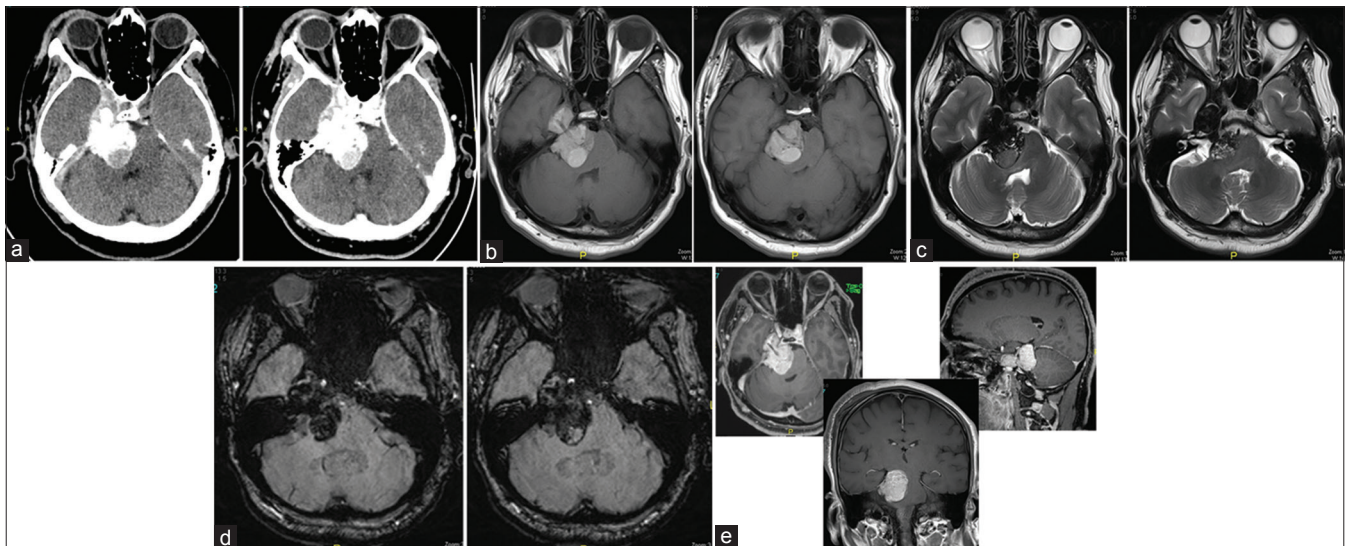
(a) Axial CT sections before and after IV contrast administration showing right-sided CP angle extra-axial mass lesion of mixed high and iso-attenuation value showing faint postcontrast enhancement extending over the petrous apex to the right parasellar region medial to the right temporal lobe. (b) Axial T1-weighted images showing lobulated intracranial extra-axial hyperintense lesion at the right CP angle and creeping along the petrous apex to the right parasellar region compressing the brain stem and indenting the medial aspect of the right temporal lobe. (c) Axial T2-weighted images showing the complex texture of the lesion with predominant low signal intensity and cystic areas of iso to high signal intensity. (d) Axial susceptibility-weighted images (SWI) showing ferromagnetic effects of the contents of the lesion with patchy areas of low signal intensity within a cystic lesion. (e) Axial, sagittal, and coronal contrast-enhanced T1-weighted images of the brain showing increase in the hyperintensity of the lesion denoting its enhancement and showing the extension of the lesion from the right CP angle region to the right parasellar region with its mass effect on the brain stem and the right temporal lobe
